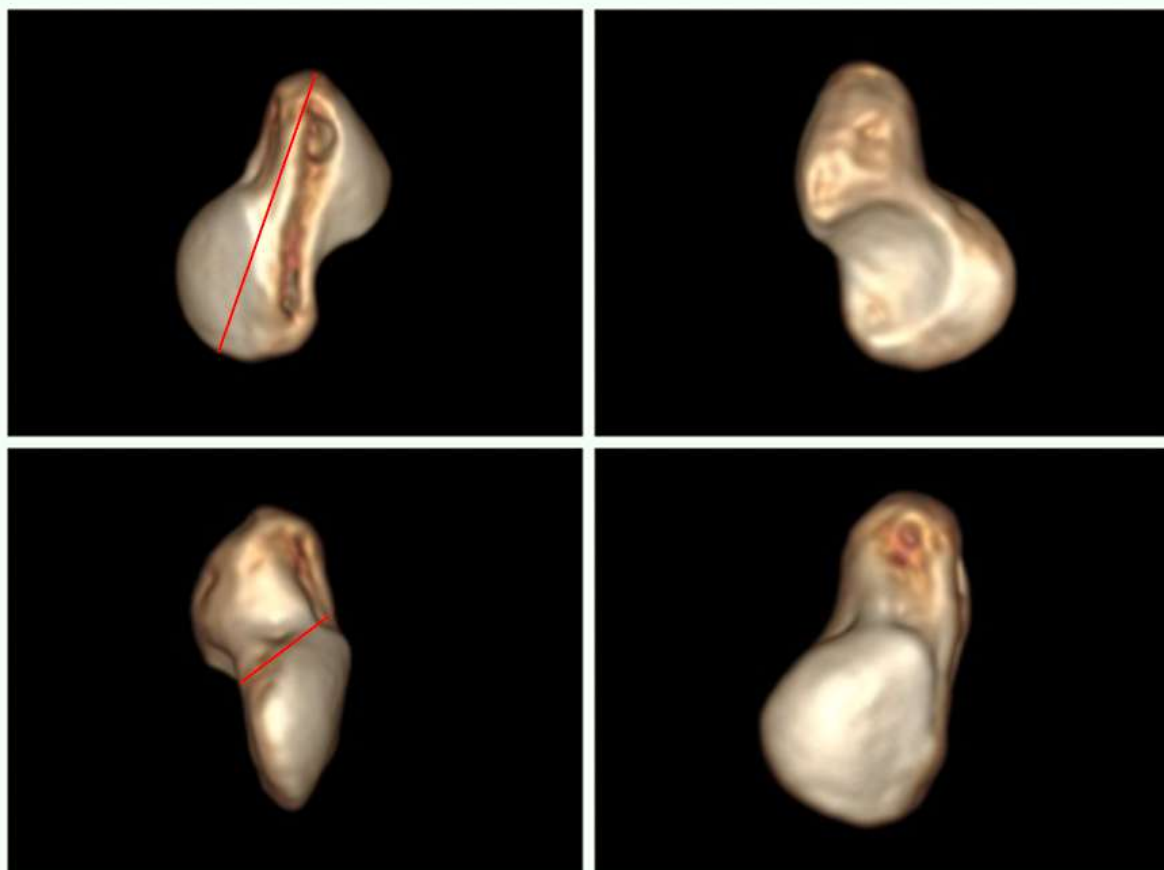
Three-dimensional CT reconstruction image for digital measurement.
